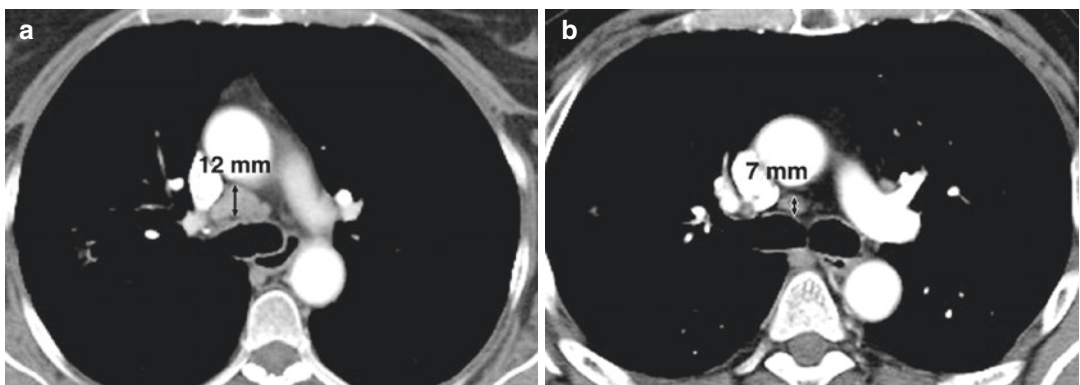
Assessment of pathologic lymph nodes by RECIST 1.1 on CT scan of patient with lung cancer. (a) Subcarinal lymph node measures 12 mm in short axis (arrow) on chest CT, so it should be considered as nontarget lesion according to RECIST 1.1. (b) Precarinal lymph
